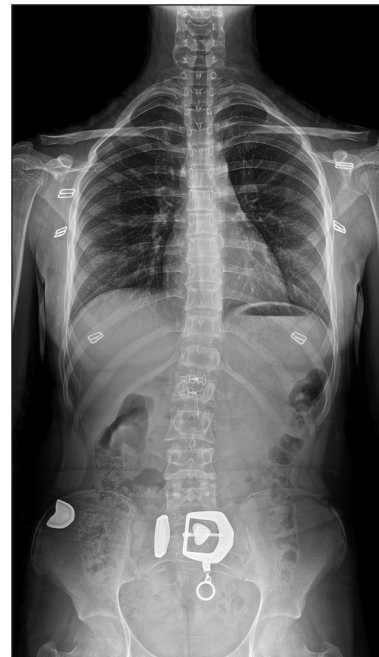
Scoliosis in the left thoracolumbar region and sacralization (Vertebral X-ray).
